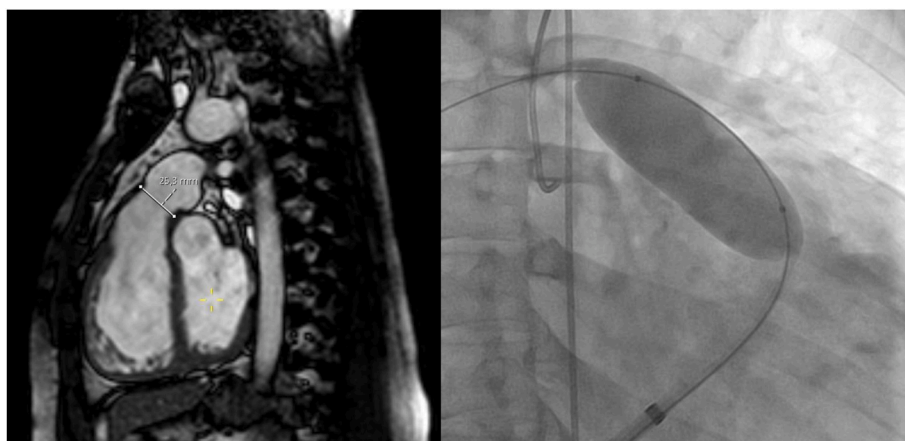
a. Pre-procedural CTA with an MPA diameter of 25,3 mm. 7b. Unstable 30 × 40mm balloon in RVOT with passing of contrast (poorly visible in still frame).
